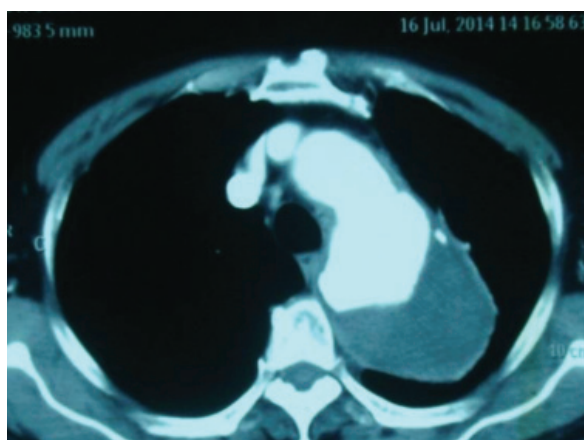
Computed tomography scan revealed a large saccular aneurysm at distal aortic arch.
